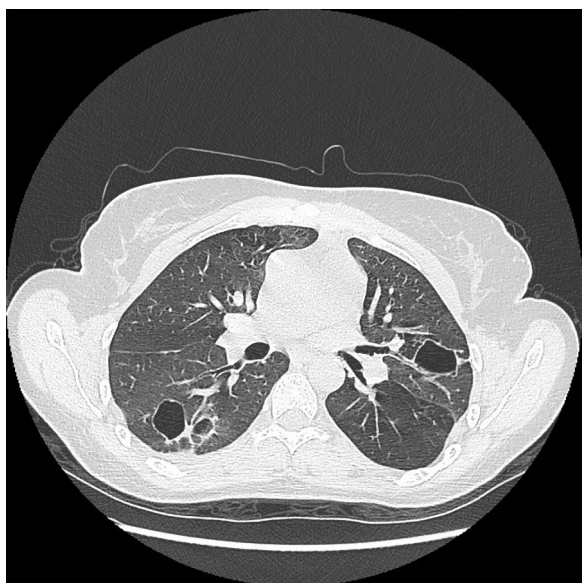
Computed tomography of the mother's thorax.
